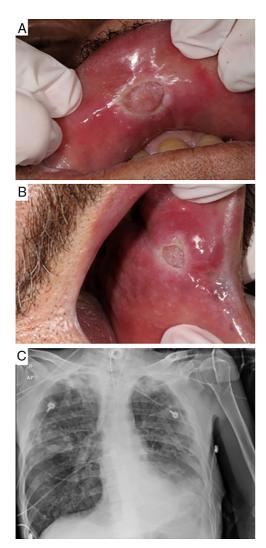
Clinical aspects of oral TB lesions and lung radiographic findings. Ulcerative lesions with granulomatous center and whitish halo on the upper labial mucosa near the median line (A) and on the left jugal mucosa, near the labial posterior commissure (B). Full radiograph of the lower left pulmonary lobe. Presence of active disease manifested as budding tree-like centrilobular nodules in both lungs, especially on the right (C).
